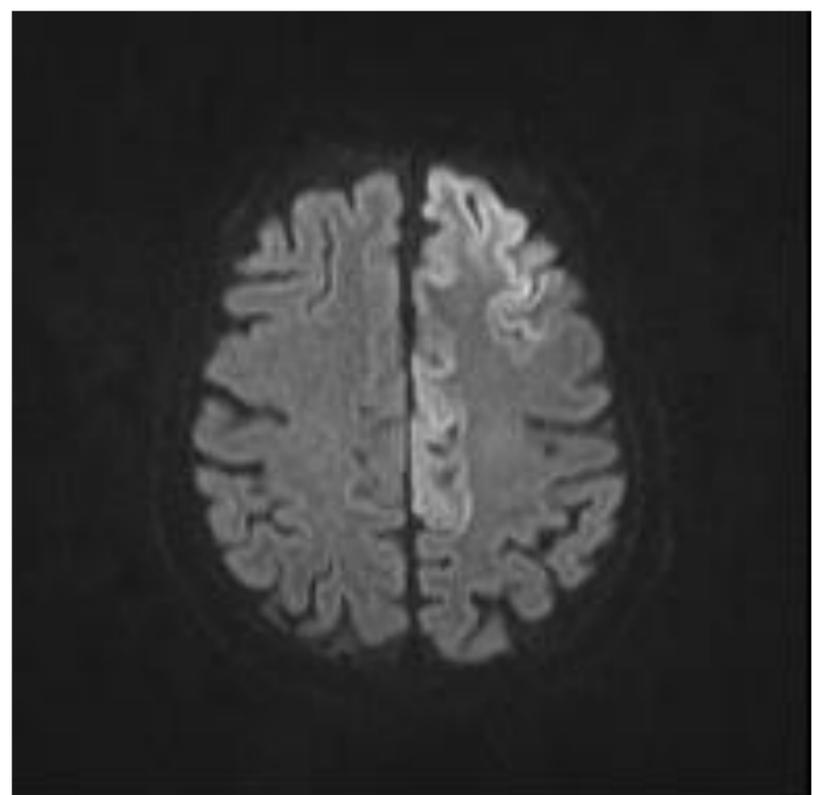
Brain MRI DWI hyperintensity left fronto-insular cortex
